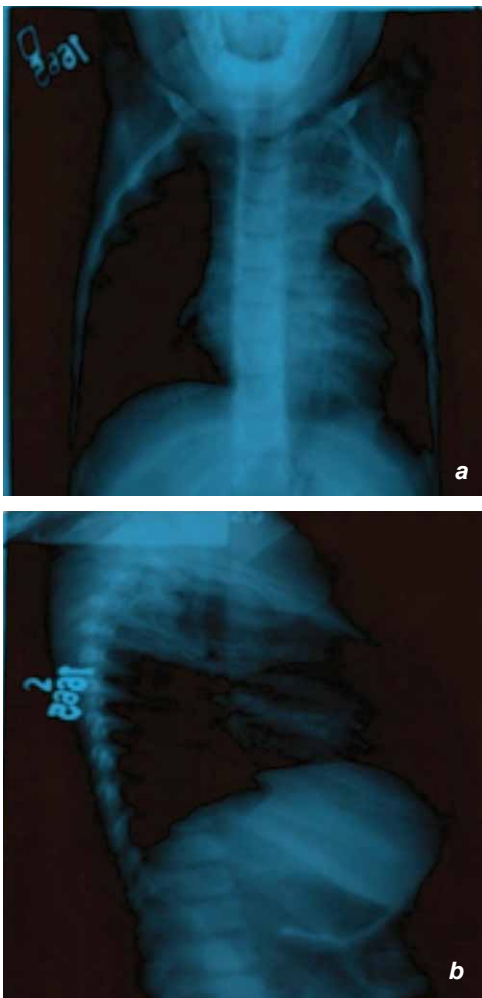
Chest X-ray, a – postero-anterior, b – lateral
